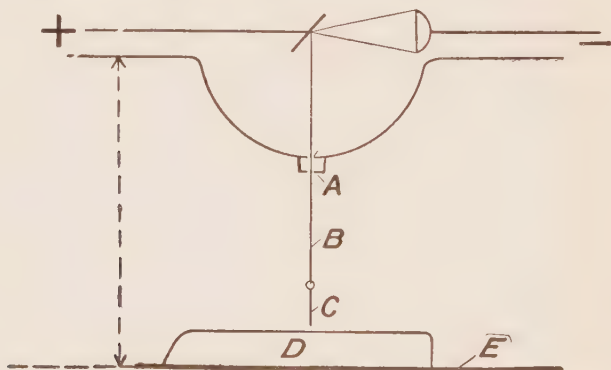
Shows the best position to place the plate in relation to the X-ray tube. "E" represents the X-ray plate, "D" the part to be radiographed, "A" represents a cork having a thread passed down through the center of it "B" and a pointer attached to the lower end "C." This pointer should come over the central portion of the X-ray plate!
